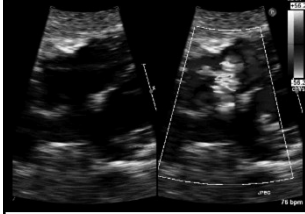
Image from Sridharan S., Price G., Tann O, et al. Cardiovascular MRI in Congenital Heart Disease: An Imaging Atlas. 2010
